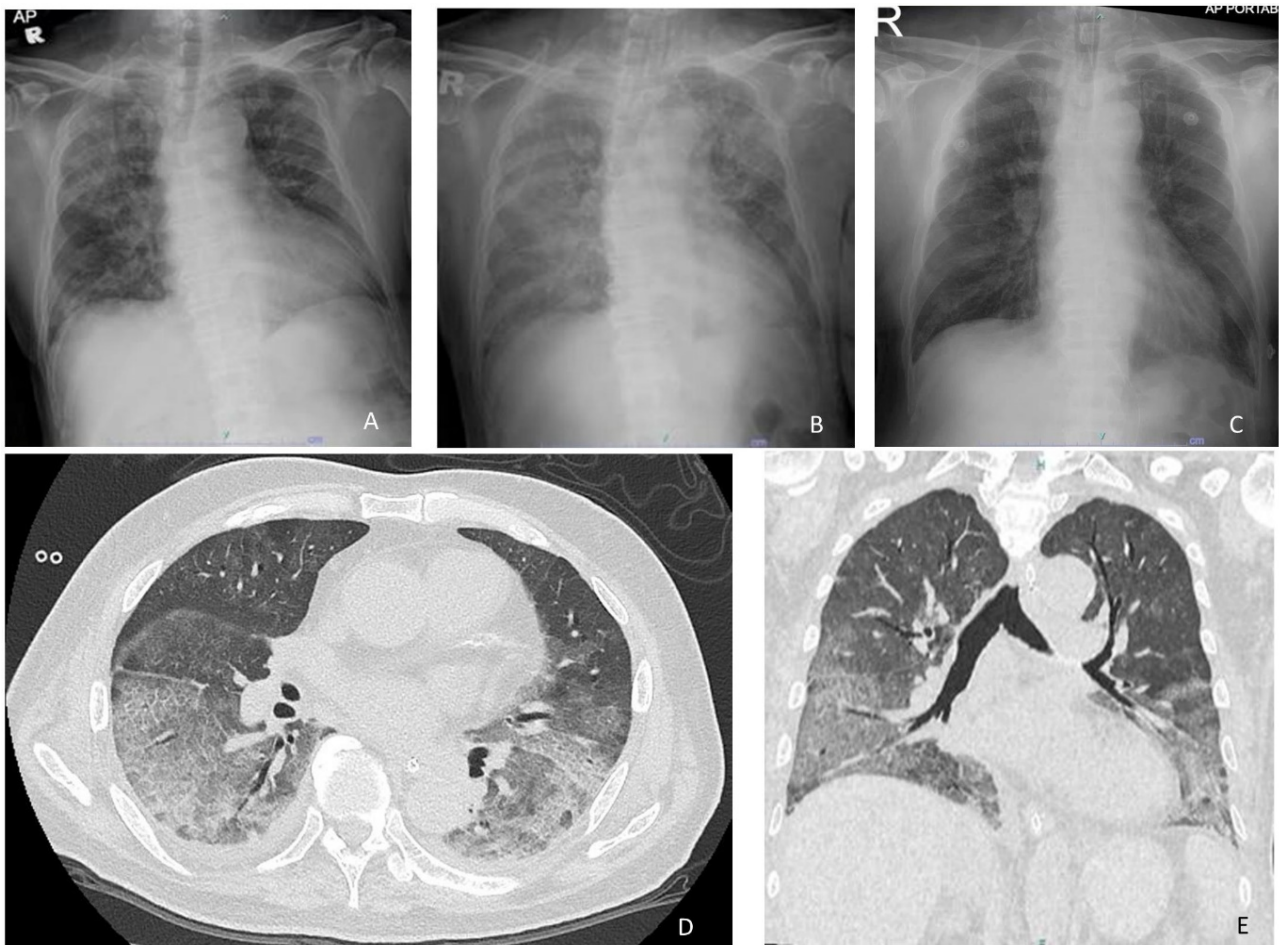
(A) Chest radiograph showing right upper zone air space opacities. (B) Chest radiograph showing diffuse alveolar opacities. (C) Chest radiograph 48 hours after methylprednisolone showing remarkable improvement of the alveolar opacities. (D & E) High resolution computed tomograph of the thorax showing diffuse ground glass opacities with interlobar septal thickening.
